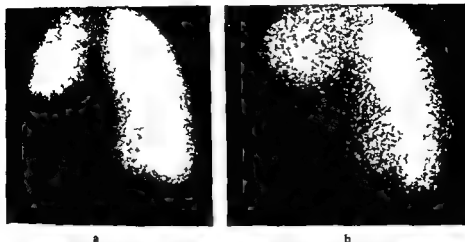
a) Perfusion scintigraphy. Patient with atelectasis in the right lower lobe. No perfusion through the affected lobe. Anterior projection. b) Ventilation scintigraphy. Same case as in (a). No ventilation in the affected lobe.
